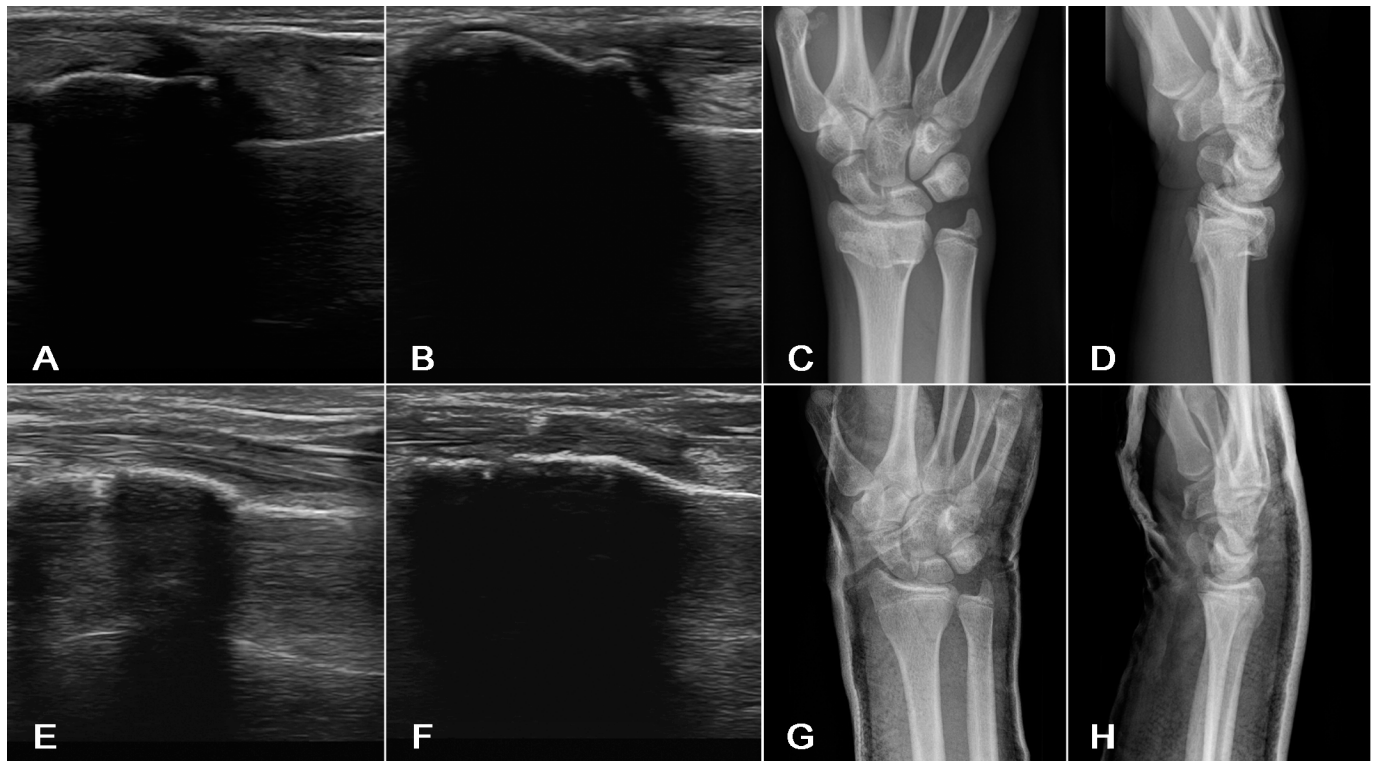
Ultrasound and radiographic images before and after reduction: (A) ultrasound image pre-reduction dorsal view, (B) ultrasound image pre-reduction radial view, (C,D) pre-reduction radiograph, (E) ultrasound image post-reduction dorsal view, (F) ultrasound image post-reduction radial view, (G,H) post-reduction radiograph.
